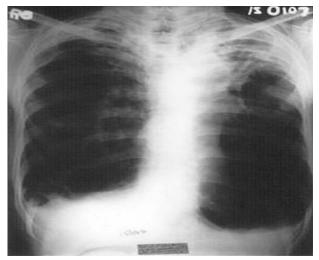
Chest radiograph showing a large bulla in the left lower zone with concavity of the left dome of diaphragm.
